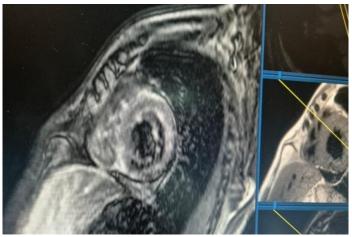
Cardiac MRI: non-dilated LV with diffuse myocardial hypertrophy, preserved systolic function at 55%, diffuse late sub-endocardial enhancement of the LV, atria and SIA
